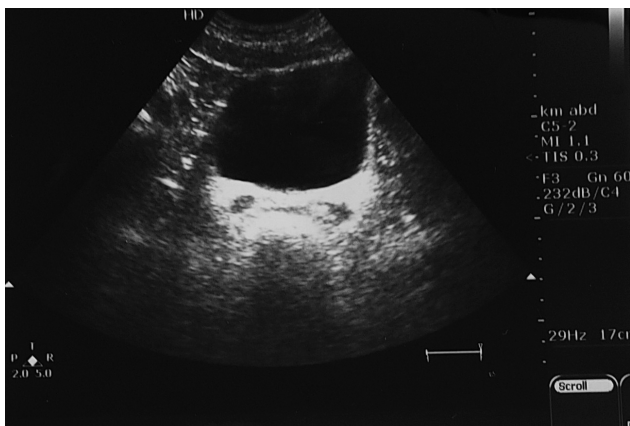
Abdominal ultrasound: The vermiform appendix is not visualized, and no free fluid is found. The only finding was probe tenderness in the right iliac fossa.
